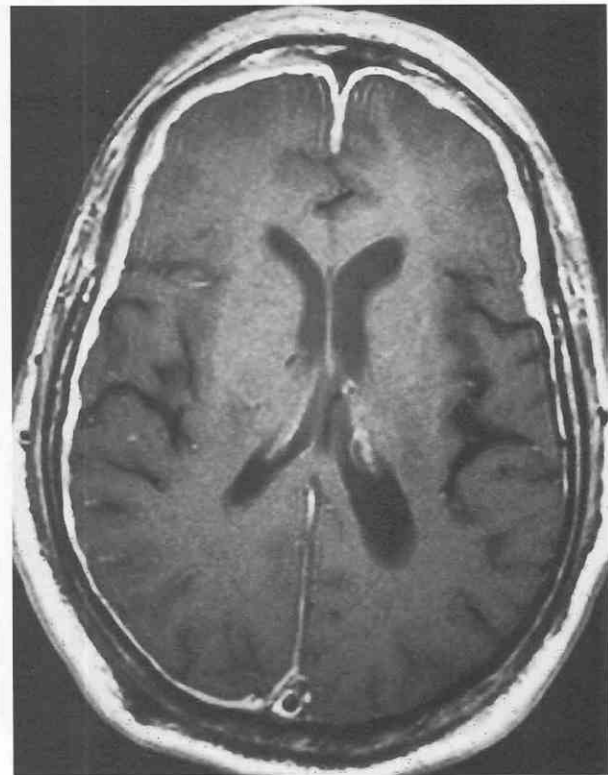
Chronic meningitis. Thick, slightly irregular dura/arachnoid enhancement on axial T1-weighted imaging proved to be idiopathic hypertrophic pachymeningitis on biopsy.
